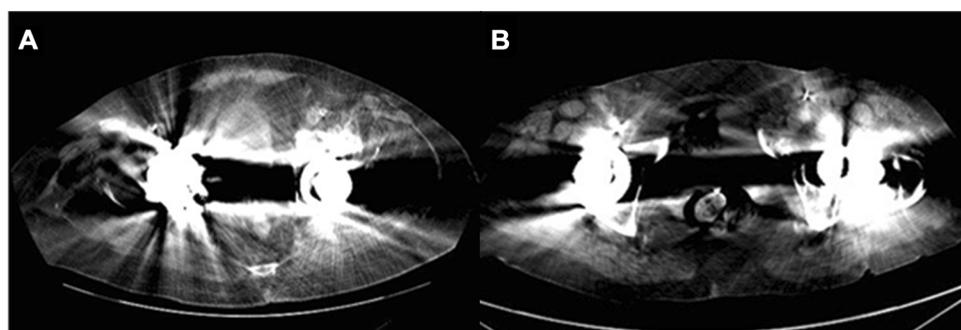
Image quality degradation due to bilateral metallic hip implants in two different patients. A Axial contrast-enhanced CT image in a 82-year-old patient with prostate cancer shows that the artifacts from the B/L hip implants limit evaluation of prostate and internal iliac nodes rendering this study diagnostically unacceptable (DA score 1). B Axial
